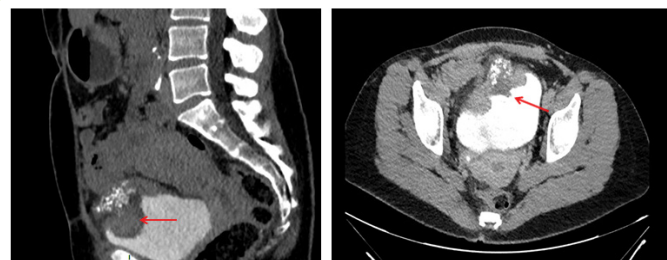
Postpartum computed tomography reveals a 8-9 cm tumor located between the urachal ligament and the bladder dome.
